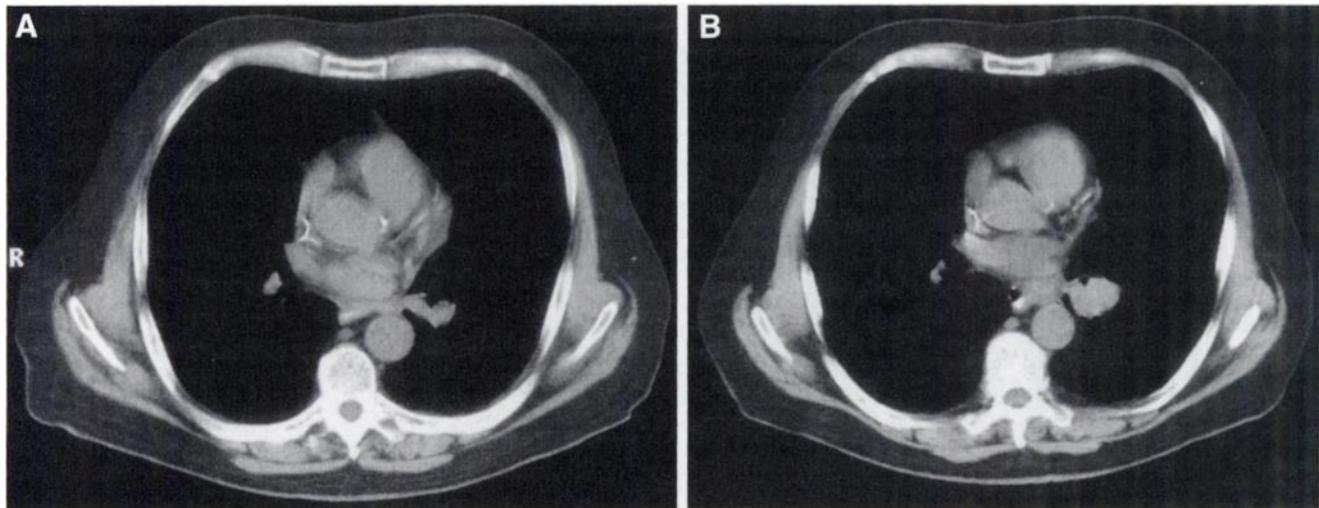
Axial CT images obtained in patient presented in Figure 3 at same time points. (A) At end of chemotherapy, no abnormality was seen in left hilum, which had remained anatomically stable compared with prior studies. (B) After 6 mo, definite mass is seen in left hilum and in parahilar region matching gallium findings. Gallium findings preceded anatomic changes in patient.
